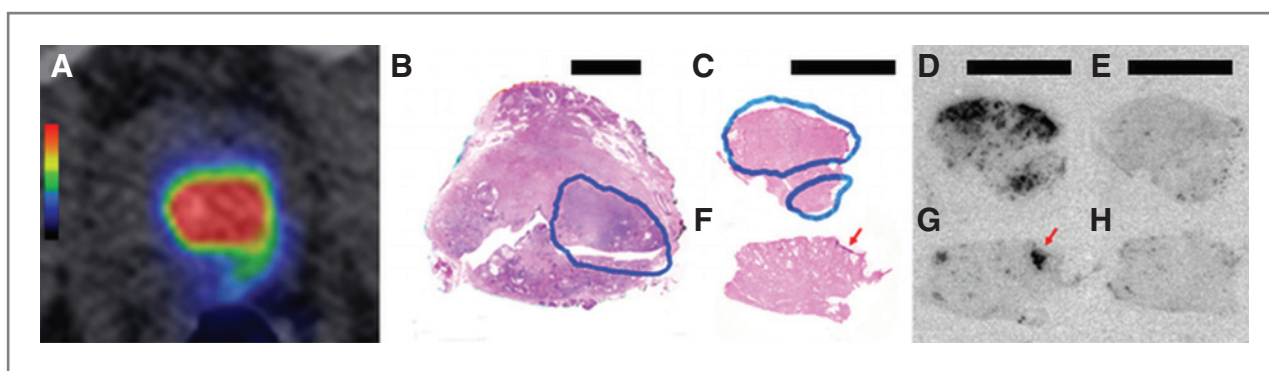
BAY86-7548 PET/CT (A) of patient no. 10 showing uptake in the left lobe of prostate gland in the area of cancer based on whole-mount prostatectomy sample. B, tumor is outlined in blue. Bar, 1 cm. ARG showed presence of GRPr in the section taken from the left lobe (D, top; bar, 1 cm) in the area of cancer (C, top, tumor is outlined in blue; bar, 1 cm), whereas only small areas of HGPIN in the section taken from the right lobe had positive activity (F and G, bottom, red arrow points to the area of HGPIN; bar, 1 cm). The presence of 1 mmol/L bombesin blocked uptake of [125 I]-Tyr⁴-bombesin-14 in the sections from left (E, top right) and right (H, bottom right) lobe. BAY86-7548 PET/CT image is scaled to SUV, with a minimum at 0 and maximum at 5.
